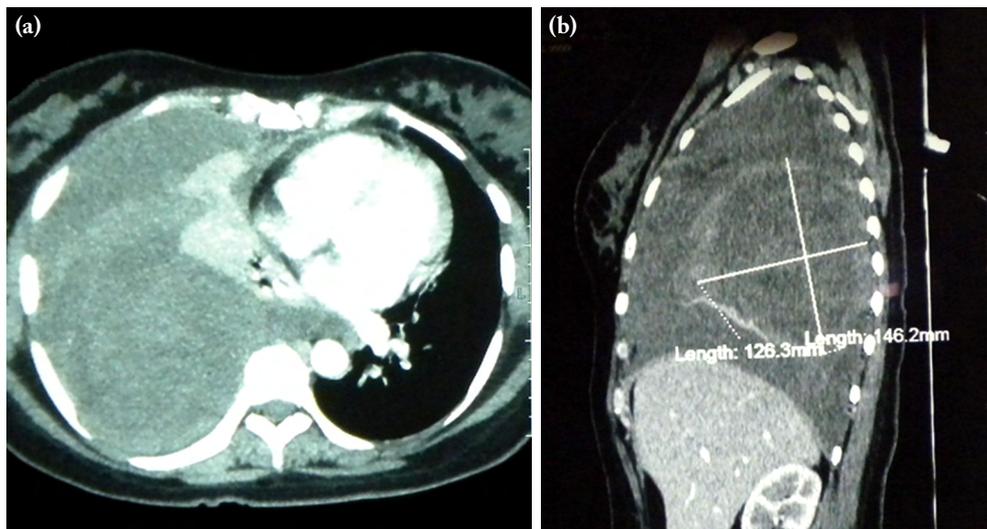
Thoracic computed tomography showing (a) massive hemothorax and (b) mass of the posterior mediastinum.
